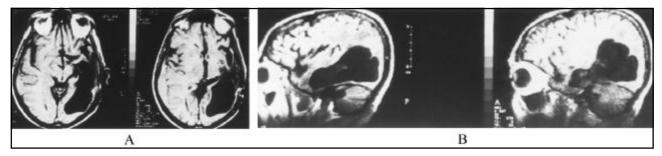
Postoperative MRI in transversal (A) and sagittal (B) view showed a radical tumor removal.
